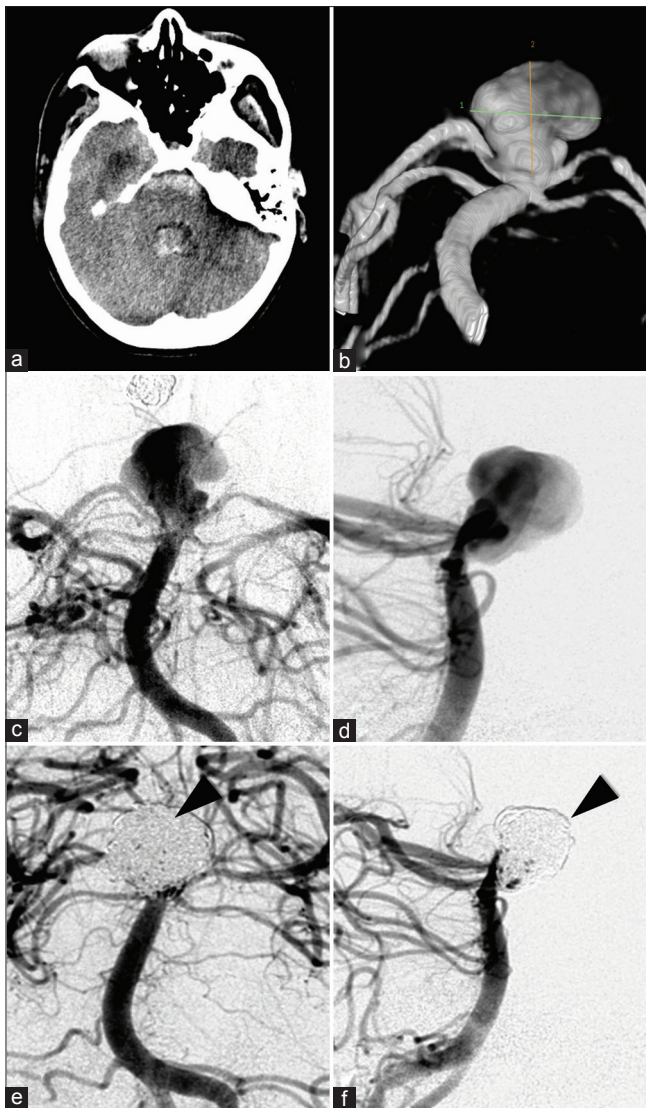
Rapid decline of patient on PBD#26 demonstrated new SAH on CT scan (a) and redemonstration of previously thrombosed basilar apex aneurysm on catheter angiography (b: 3D reconstruction; c: AP and d: lateral views), which was subsequently coil embolized (e: AP, f: lateral views). Arrowheads demonstrate coil mass in e and f.
